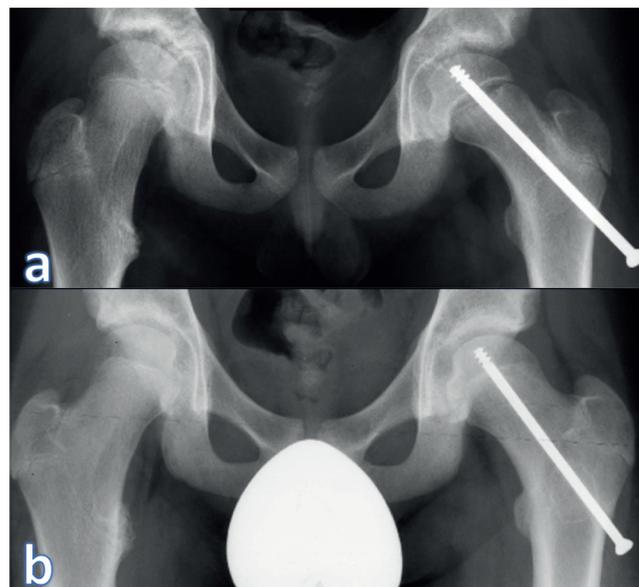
X-rays post-op (a) and after 40 months from baseline (b).
